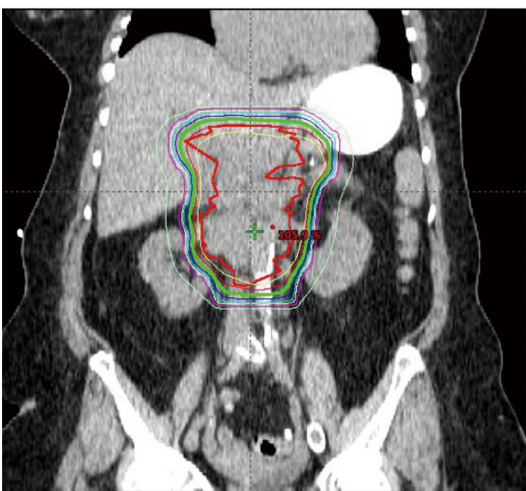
Extent of adenopathy seen on radiation planning CT. Adenopathy outlined in red. Other colored lines represent radiation isodose curves (relative doses of radiation).
